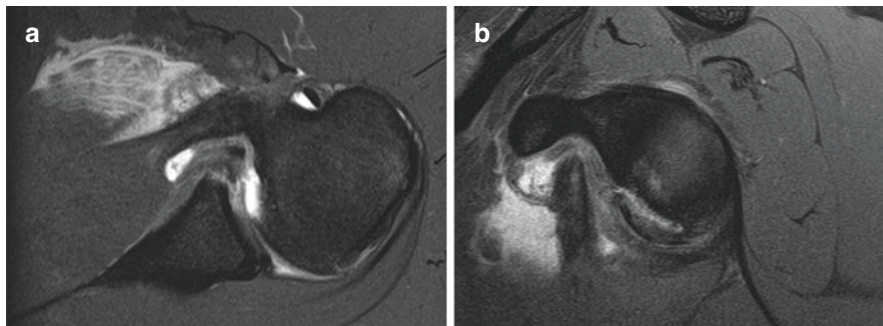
(a, b) Axillary and sagittal MRI arthrogram images demonstrating an anterior-inferior labral tear and bony Bankart lesion
